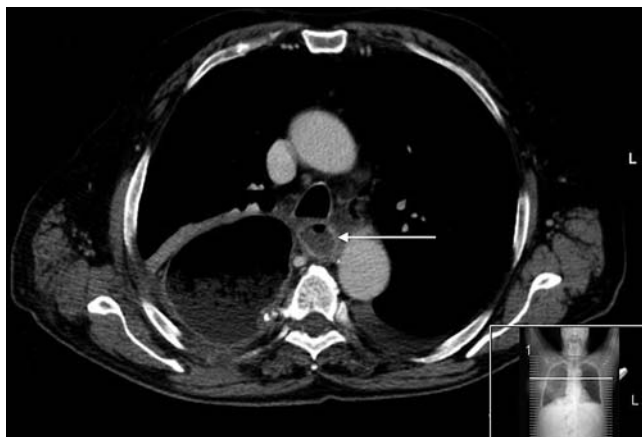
Thoracic computed tomography (CT) scan showing a posterior mediastinal collection (arrow).
